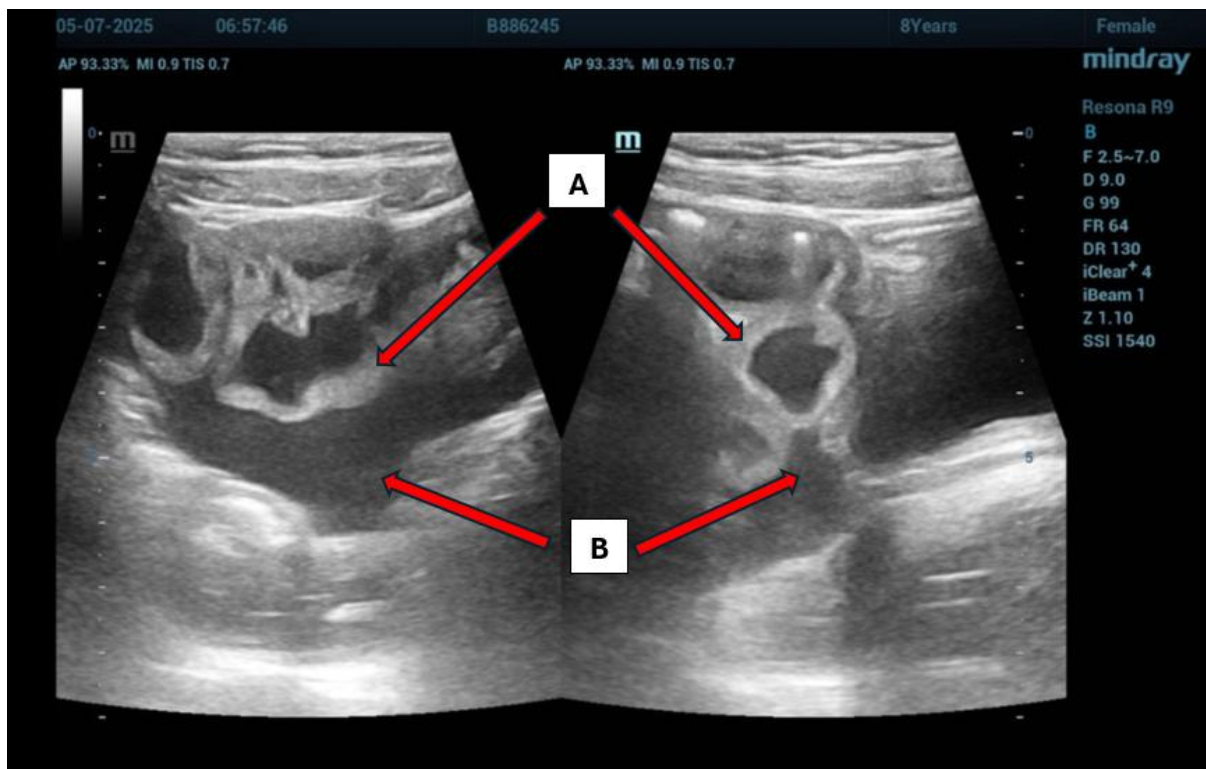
Formal ultrasound image showing interloop pelvic fluid (B) and thickened small bowel loops (A).
